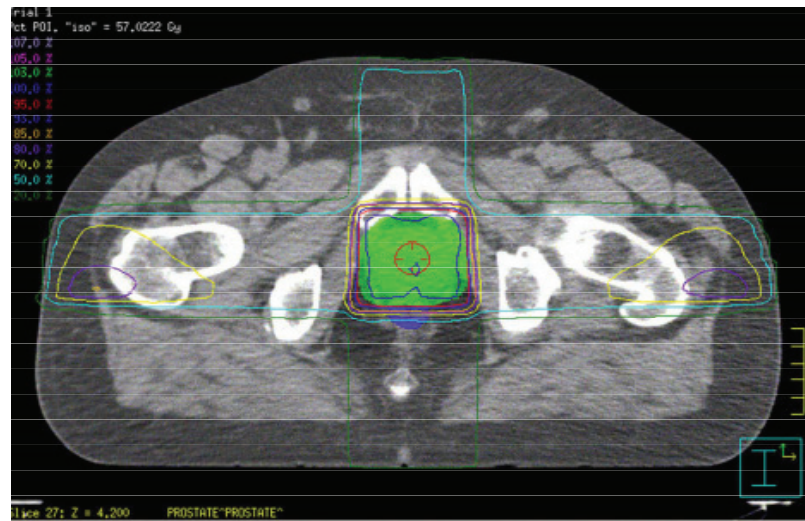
Axial CT imaging of three-dimensional conformal radiotherapy in prostate cancer with the four-field box technique. The red line (95% isodose) covered the prostate gland (green). (from Moule RN, Hoskin P. Non-surgical treatment of localised prostate cancer. *Surgical Oncology* 2009; 18: 255-267).
